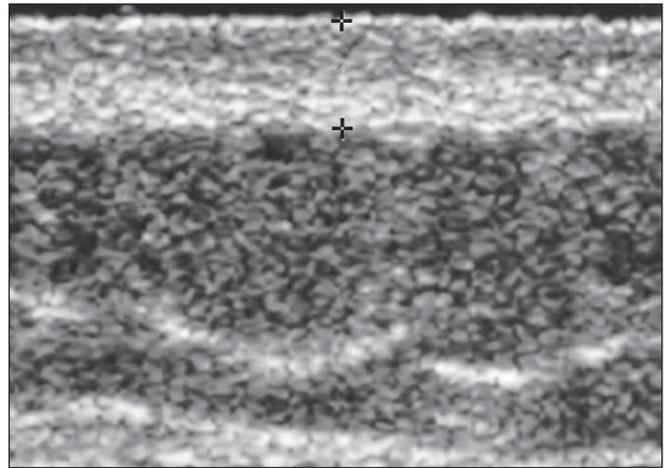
Ultrasonography of the region adjacent to an area of atrophic lesion. The typical feature of preserved skin can be observed (between crosses).
